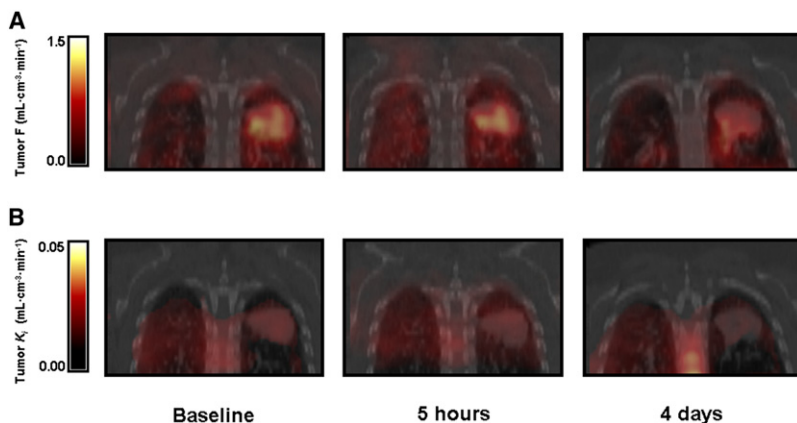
PET-CT Images of a 51-Year-Old Woman with Metastatic Non-Small Cell Lung Cancer
